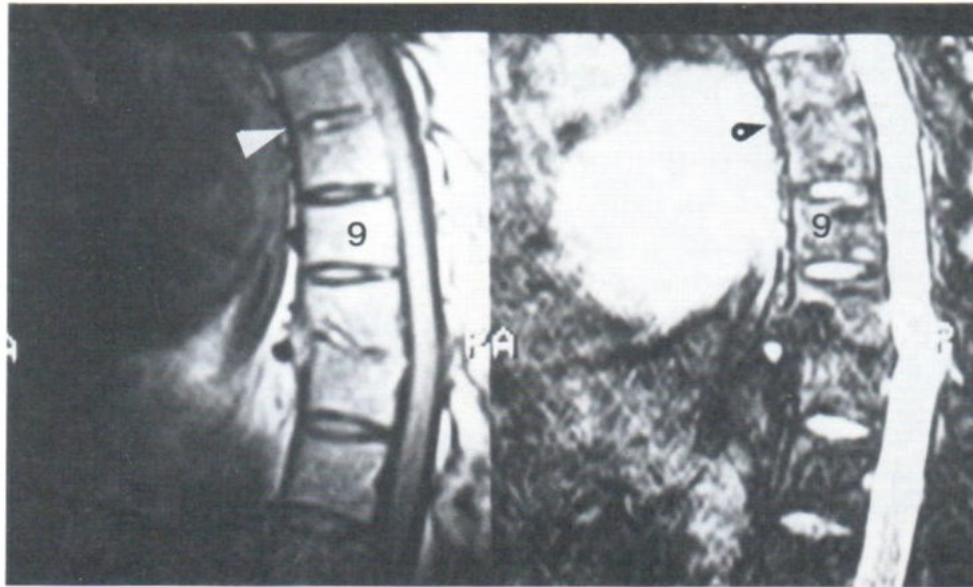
T1-weighted (left) and T2-GRE (right) sagittal MR images demonstrate that the fractured T10 and T11 bodies still have normal signal of fatty marrow. The T7-8 disk shows a spot of increased SI on T1WI (white arrowhead) and decreased SI on T2GRE (round, black arrowhead).
